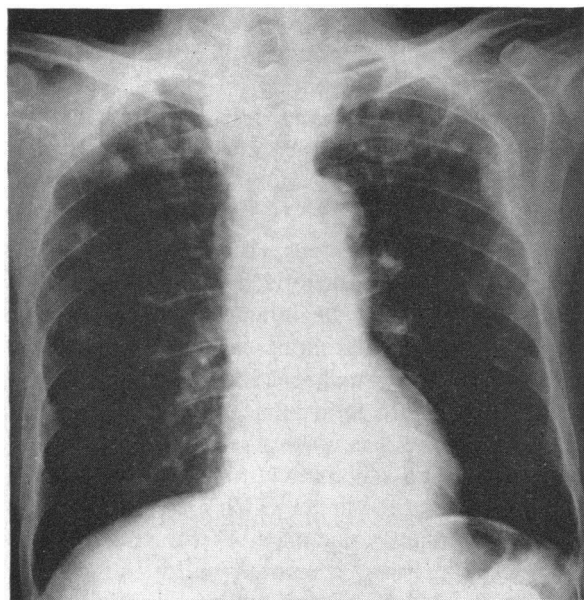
The x-ray film on admission demonstrating bilateral pulmonary densities and a destructive process evident in the left fourth rib.
